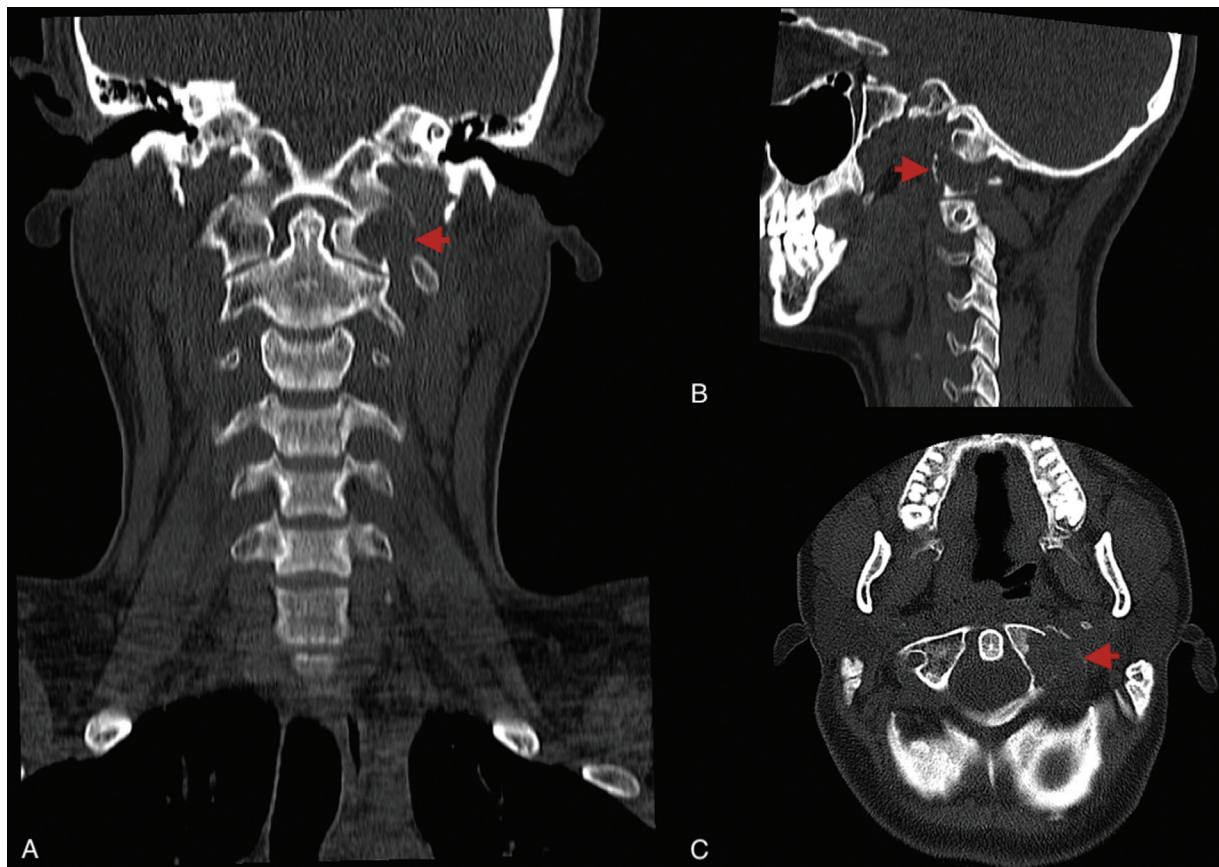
Cervical computed tomography scan with no contrast. Coronal (A), sagittal (B), and axial (C) sections showing evidence of expansive lytic lesion at the left lateral mass of the atlas.
